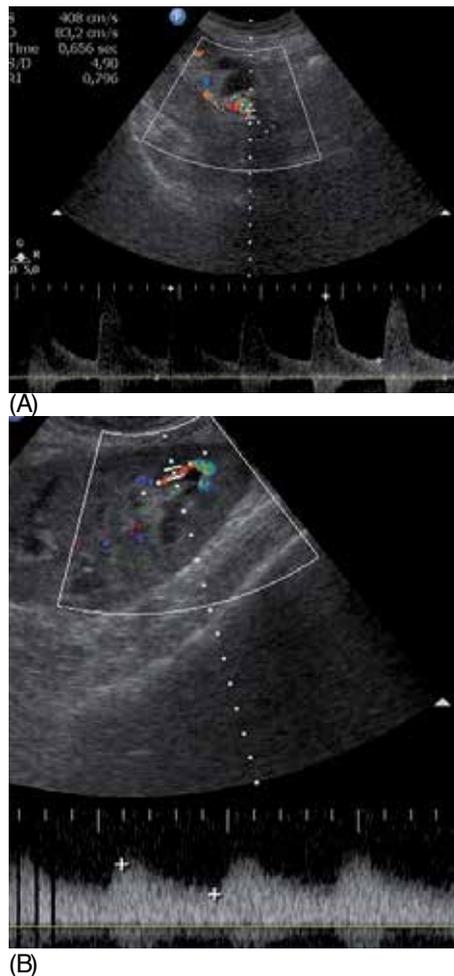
RAS. (A) Color-Doppler shows a focal stenosis near renal hilum with marked increase in PSV (4.0 m/s). (B) There is a tardus parvus waveform and a decreased RI at spectral Doppler.
